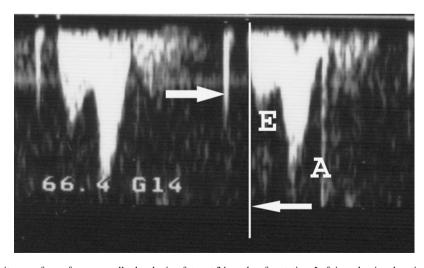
Pulsed Doppler velocity waveforms from normally developing fetus at 34 weeks of gestation. Left isovolumic relaxation time is determined from the interval between aortic valve closure artifact and the onset of E component of transmitral flow.
